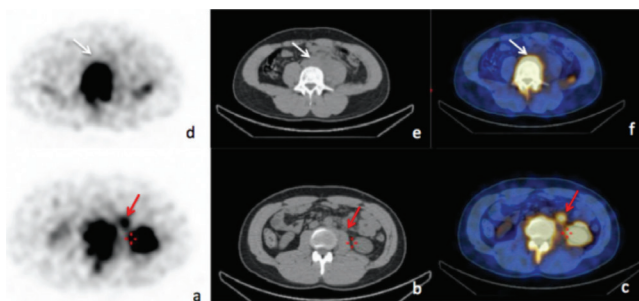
The ureter activity could not be seen in the computerized tomography (CT) sections of the mass level (white arrows), the finding may be related to the total obstruction. Single photon emission computerized tomography/CT images revealed a soft tissue mass around left ureter, which is approximately 35 mm in diameter
